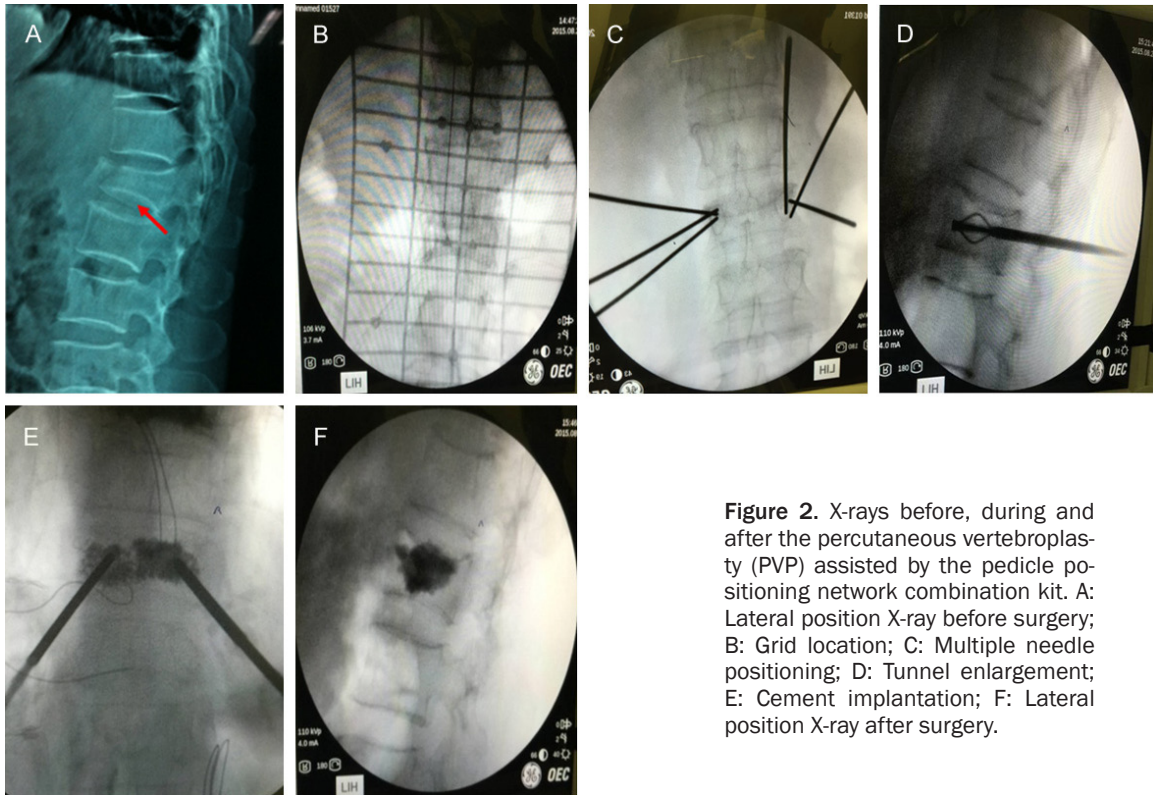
X-rays before, during and after the percutaneous vertebroplasty (PVP) assisted by the pedicle positioning network combination kit. A: Lateral position X-ray before surgery; B: Grid location; C: Multiple needle positioning; D: Tunnel enlargement; E: Cement implantation; F: Lateral position X-ray after surgery.
